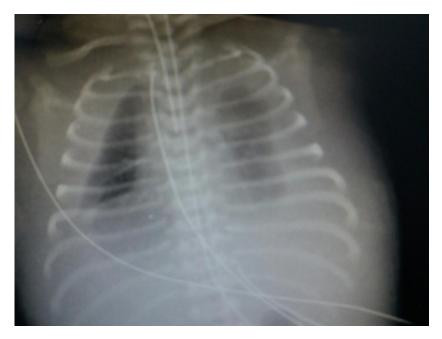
X-ray image demonstrating bilateral pleural effusions from congenital bilateral chylothorax before drain placement (clinical case number 6).
